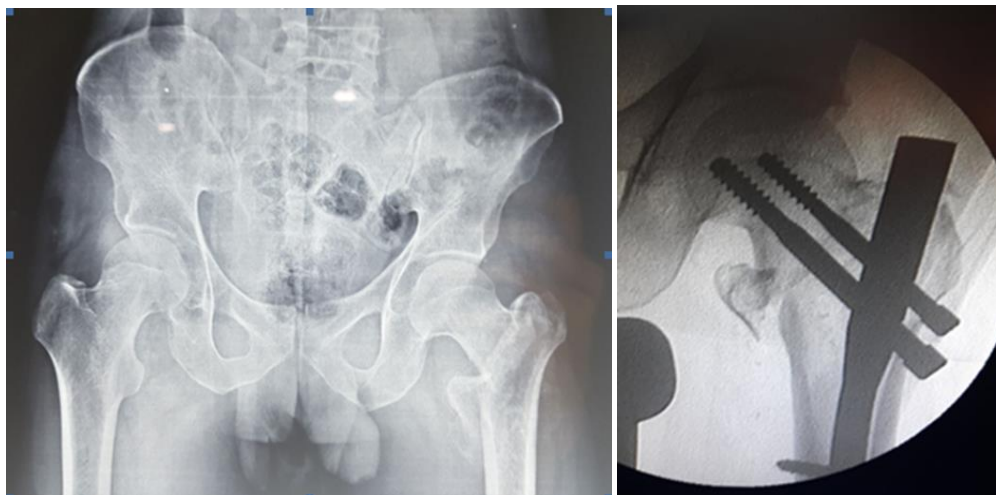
Preoperative and post-operative x-rays of PFNA Fixation
